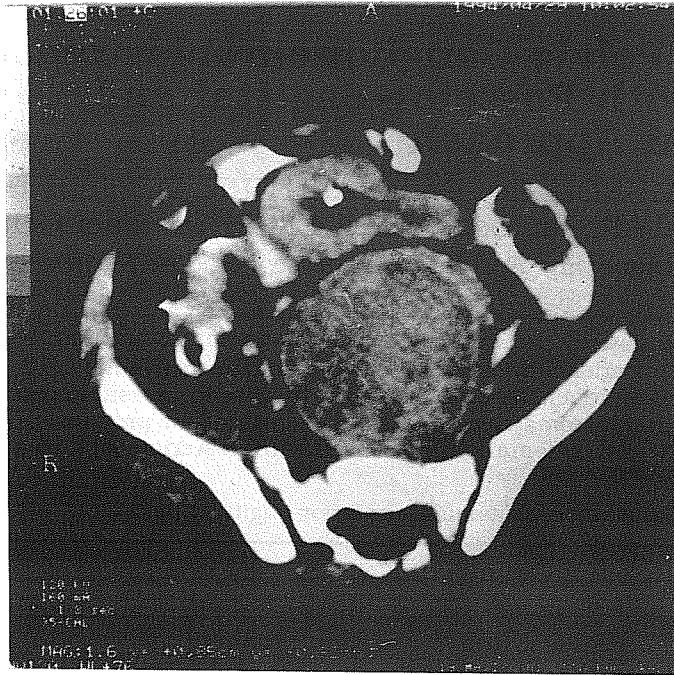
View of a 5x5,5x4,5 presacrally localised smooth shaped mass and containing nodulas in CT.
